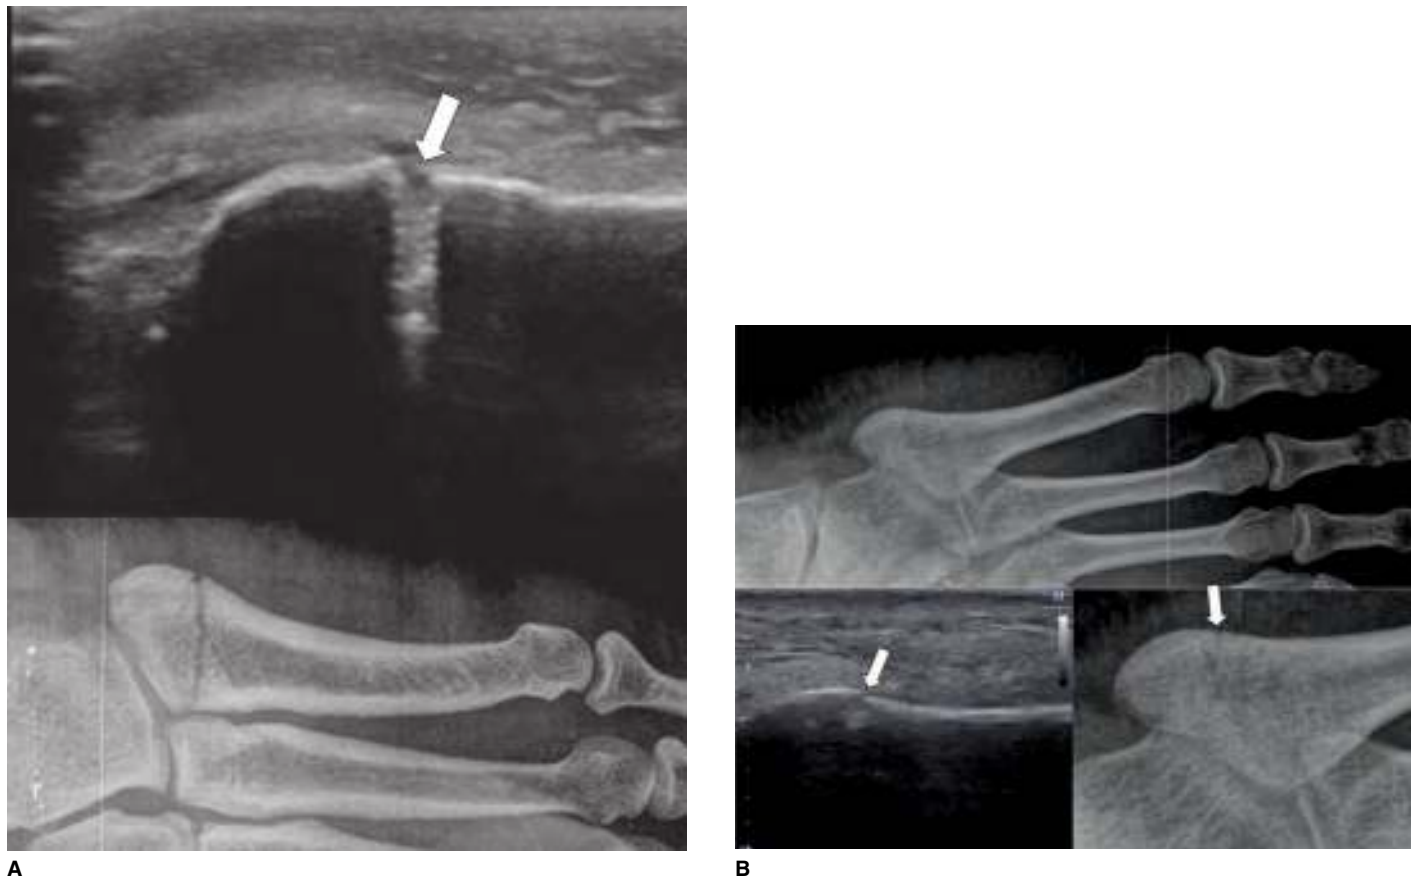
A metatarsal fracture. A. A Jones fracture on radiography is seen on the US as a cortical disruption (*arrow*). B. An avulsion fracture on the radiograph is seen on the US as cortical disruptions (*arrows*). (Used with permission from reference 30.)
